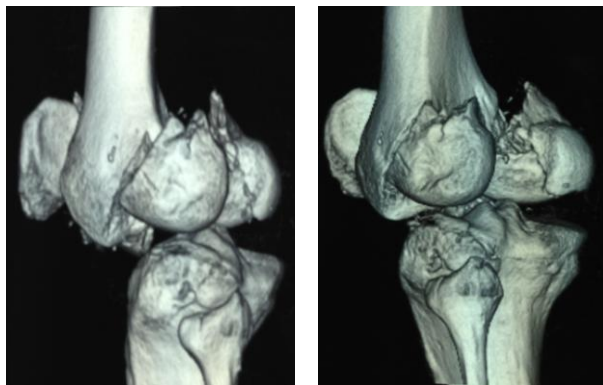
computed tomograph images showing fracture in coronal plane
